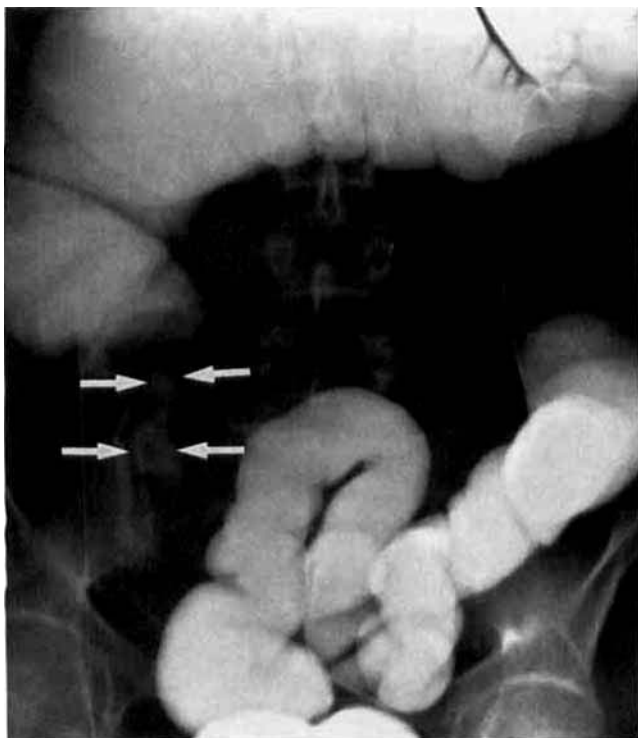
Radiologic studies in Case 1. (Top left) Gastrografin enema (day 13) showing normal filling up to the cecum, where the lumen abruptly narrows and only a thin irregular collection of contrast (arrows) is visualized. (Top right) Abdominal CT scan (immediately after gastrografin enema) demonstrating marked thickening of the cecal wall (arrows). L, cecal lumen. Thickening of the terminal ileum also appears (T). (Bottom) Abdominal CT scan (Day 35, with oral contrast) showing marked but incomplete resolution of cecal wall thickening.
